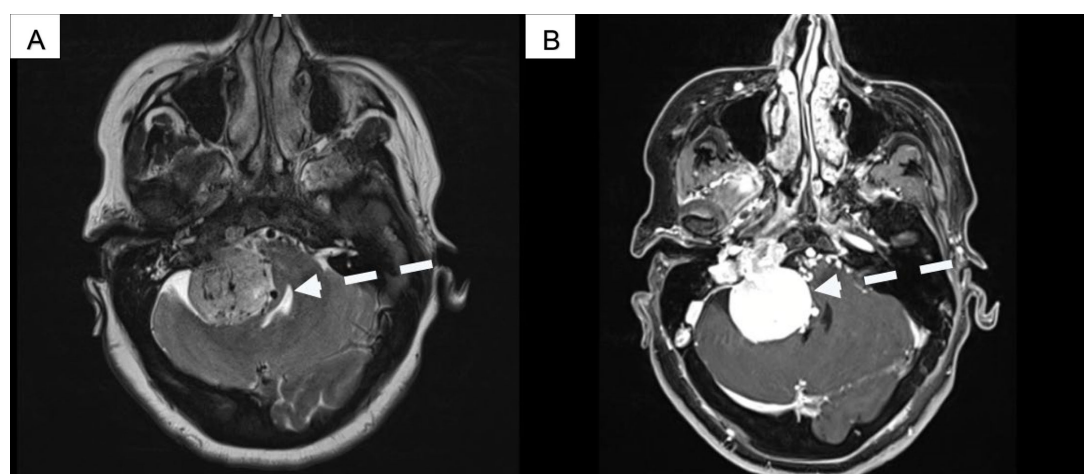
Patient axial brain MRI with T2-weighted (A) and T1-weighted with contrast (B) sequences.
